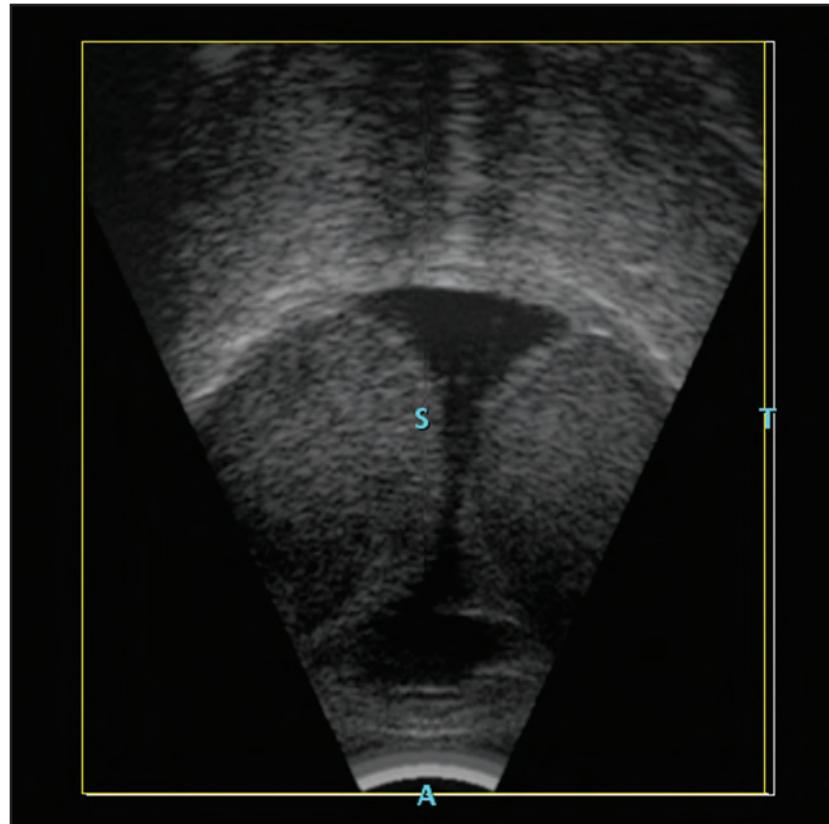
Ultrasonography demonstrates dome-shaped suprachoroidal hemorrhages.
